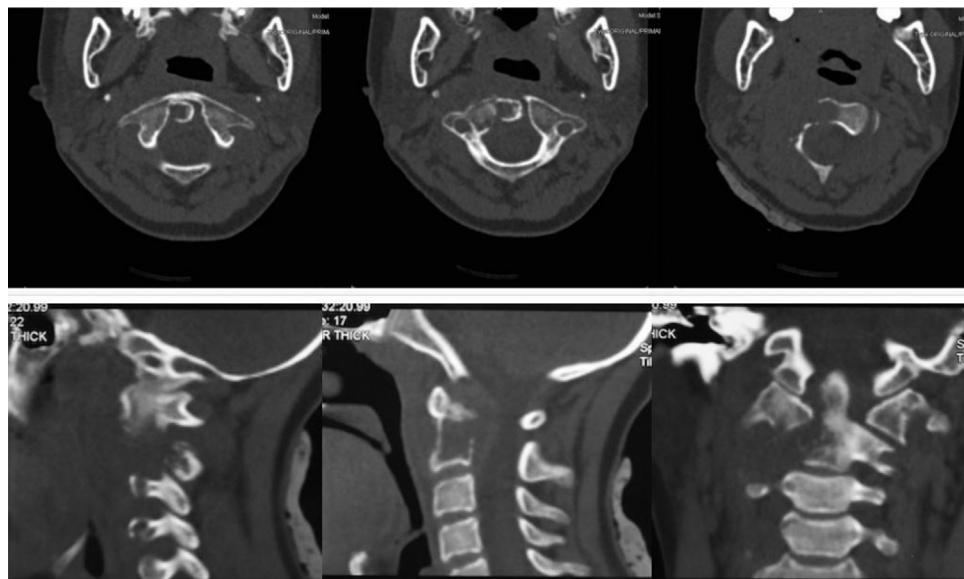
Three-dimensional computed tomography reconstruction of C1–C2 showed deconstruction for right side of C2 vertebral body and the basal part of odontoid, and the distance between odontoid and bilateral C1 lateral mass was asymmetric. This led to atlantoaxial instability.
